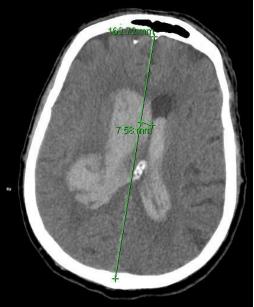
CT Scans at presentation, two hours, and five hours after presentation of a right thalamic intracerebral hemorrhage. The scans demonstrate sequential midline shift and progression of the hemorrhage into the ventricular system and adjacent tissues.
